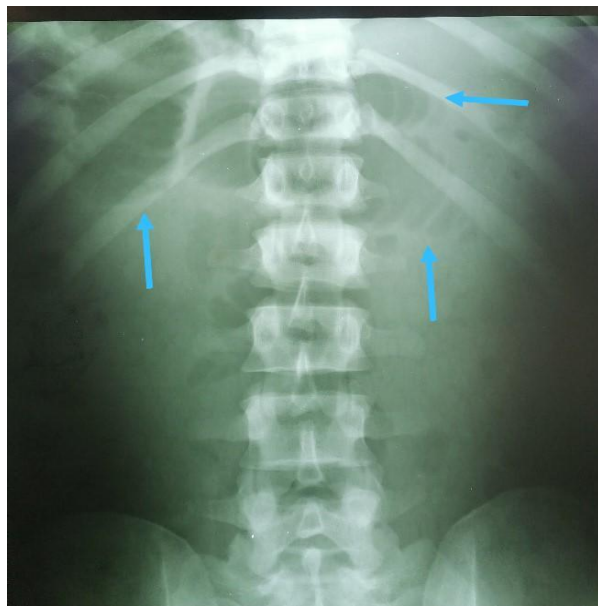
Supine abdominal x-rays, arrows showing dilated jejunum with plicae circulares
